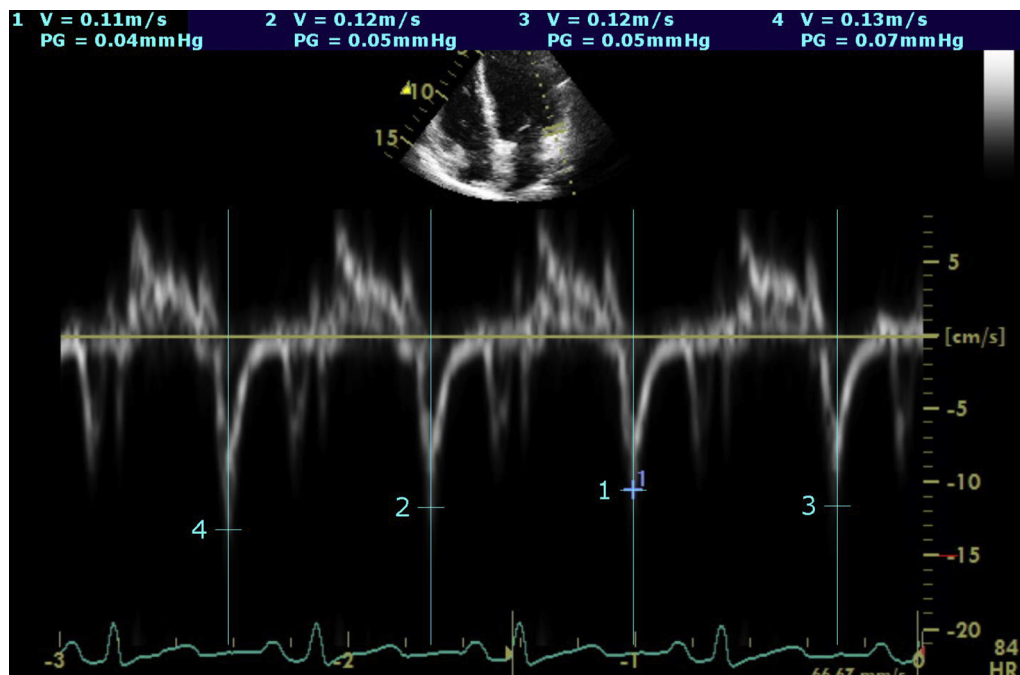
Tissue doppler imaging of the lateral mitral annular velocity revealing improvement of early diastolic mitral annular velocity measured at 12 cm/s after immunosuppression therapy.
